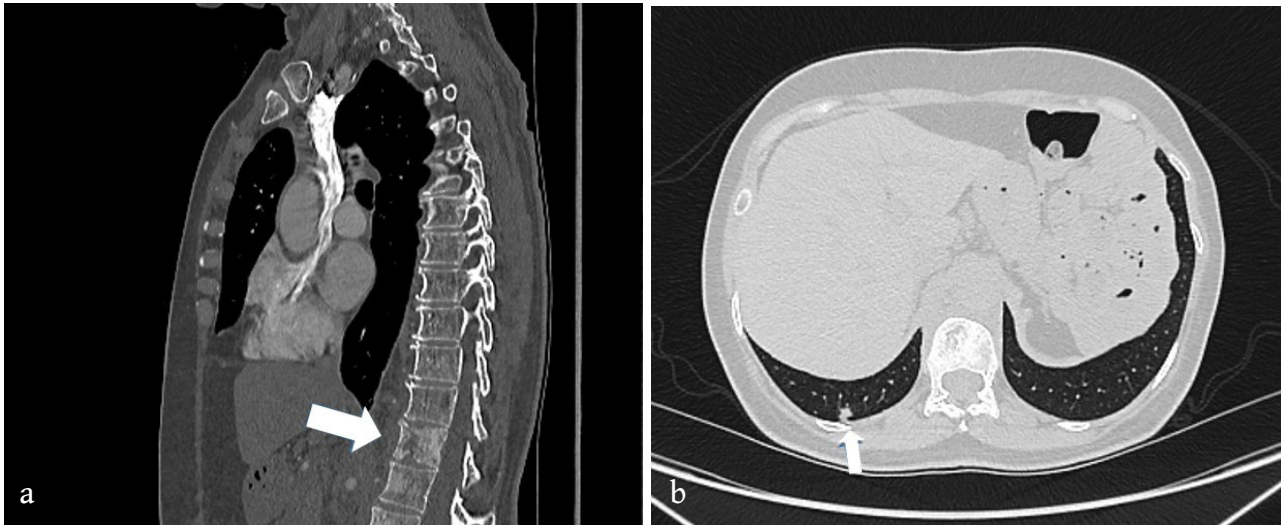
Spinal sclerotic metastasis (arrow in 1a) together with lung metastasis in the right lower lobe (arrow in 1b) are shown on CT images in a patient one year after pancreatectomy.
